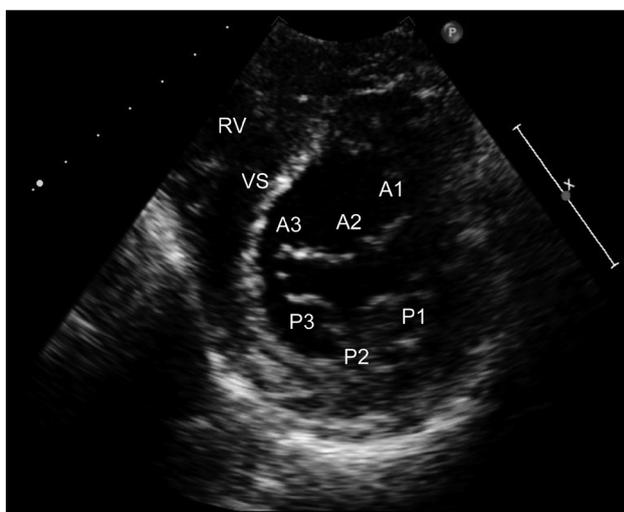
Parasternal short axis view by transthoracic echocardiography. Segmental analysis of the mitral valve. RV: right ventricle, VS: ventricular septum (see also Fig. 5).
